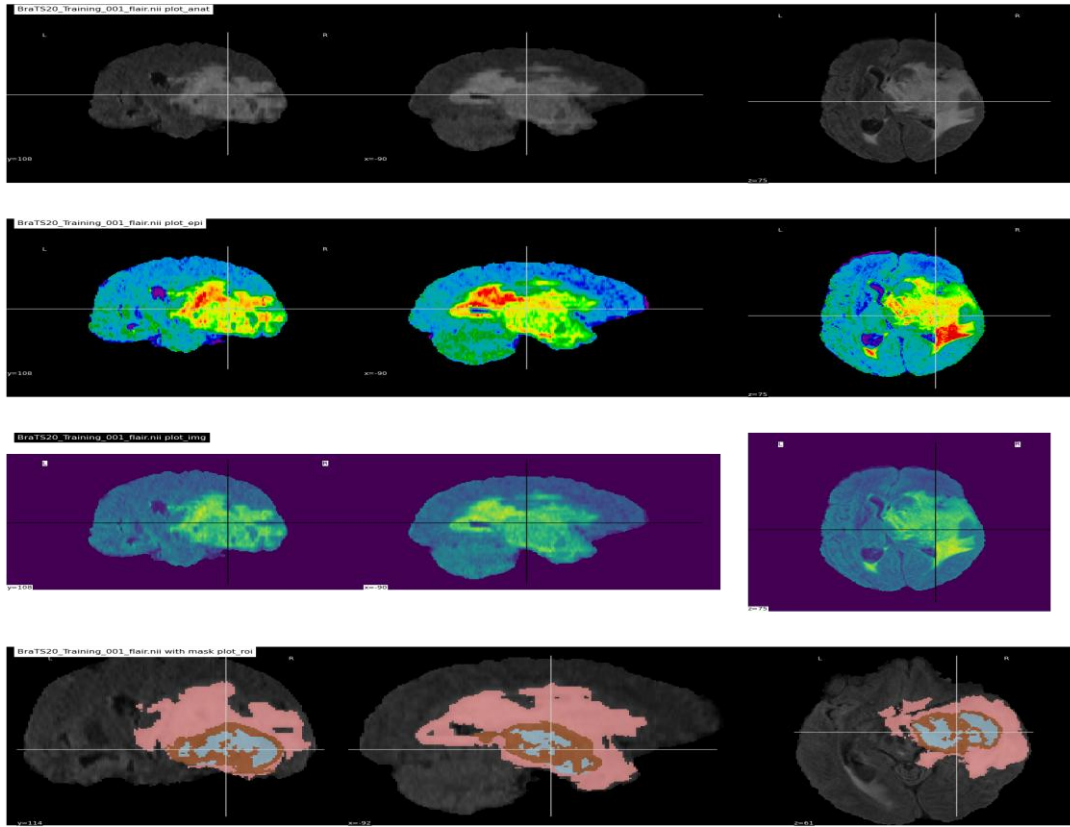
3D MRI medical images
